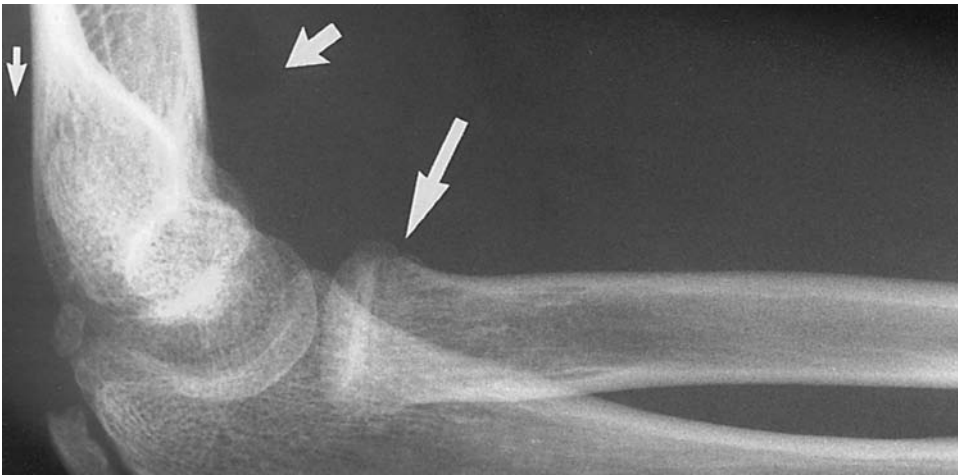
Lateral radiograph of the elbow of a 12-year-old girl, demonstrating marked elevations of both the anterior and posterior fat pads (*small arrows*). A subtle radial neck fracture is also visible (*large arrow*).
